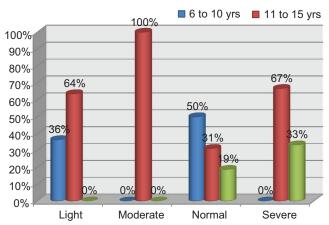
Cross-tabulation of age and MRI T2 grading
